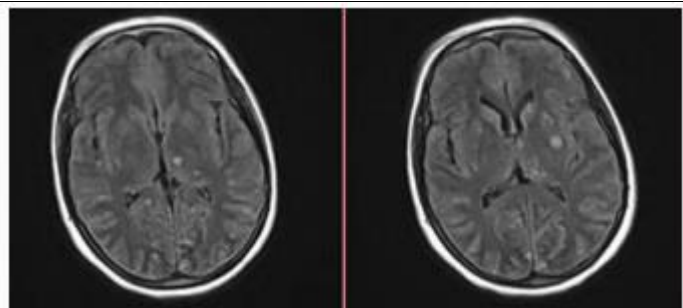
Gadolinium-enhancing nodular lesions in various cortical and sub-cortical locations are shown on T1 weighted brain MRI sections.
